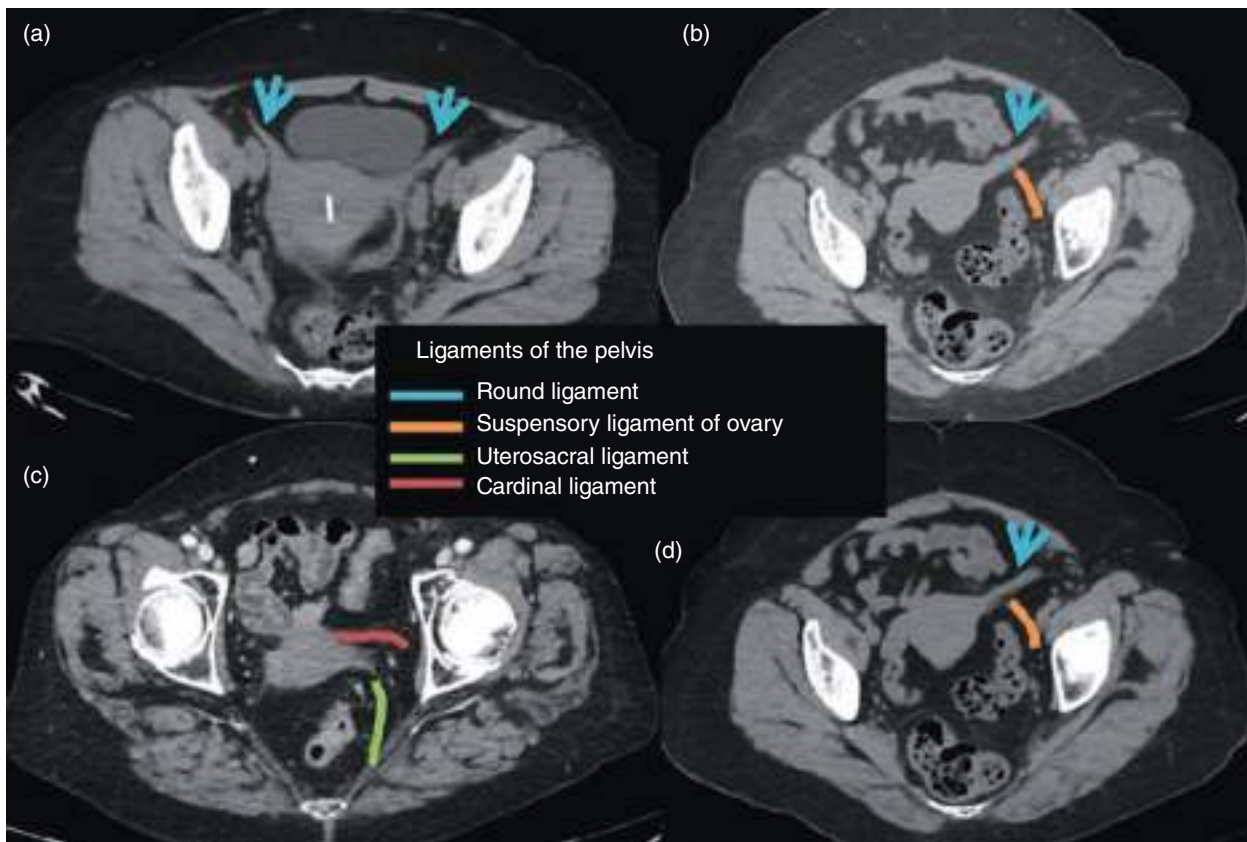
Ligaments of the pelvis. (a, b, d) Axial noncontrast CT images. (c) Axial contrast-enhanced CT image.
